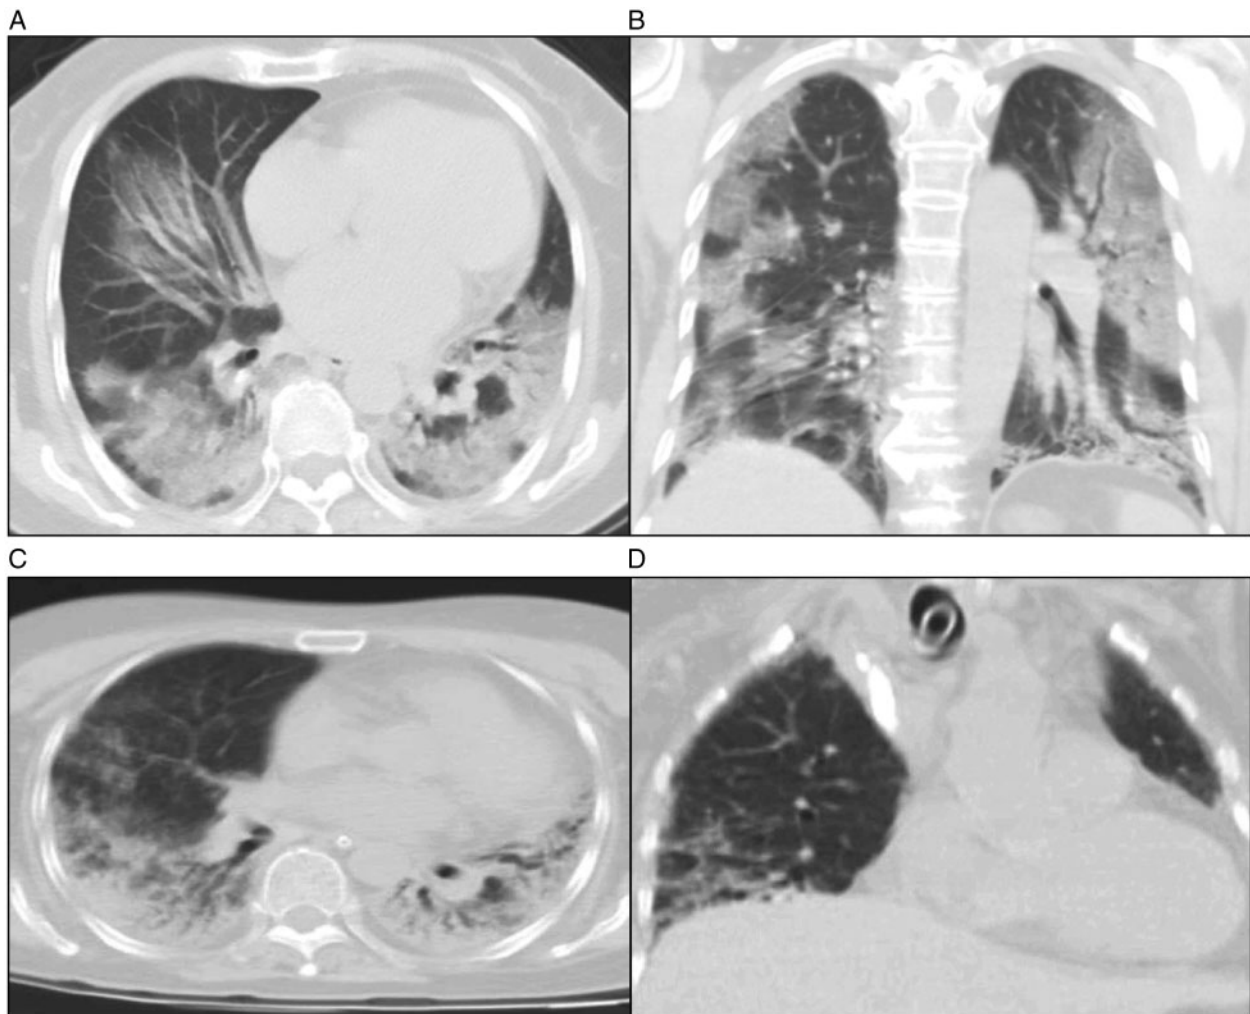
Computed tomography of the chest upon hospital admission showing ground-glass opacities and chronic inflammation of bilateral lungs (A and B). Computed tomography at 35 days after extracorporeal membrane oxygenation cannulation: the number of inflammatory infiltrates is reduced significantly (C and D).
